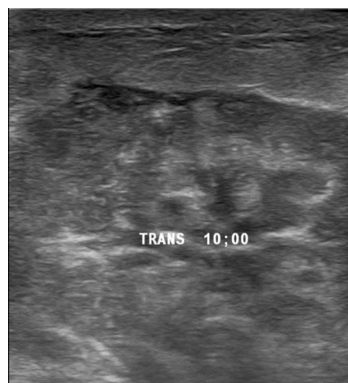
Ultrasound of the area of concern in the right breast reveals a large irregular hypoechoic mass without any evidence of abscess or fluid collection.
